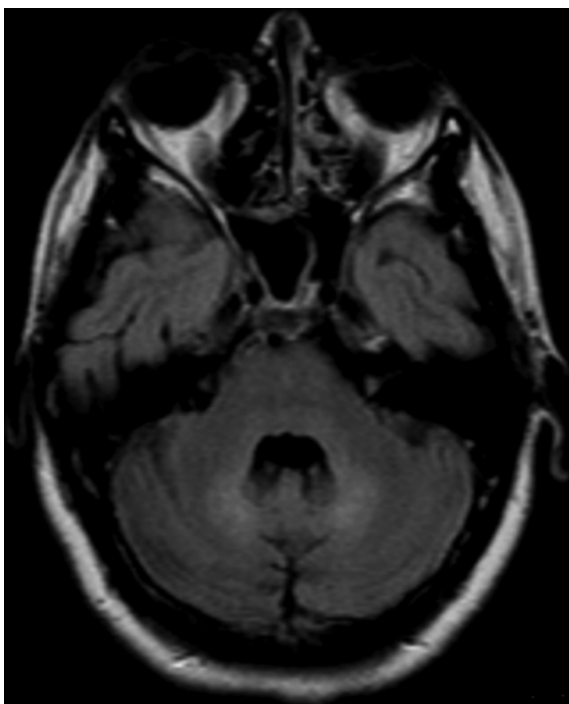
Increased signal in both cerebellar dentate nuclei in FLAIR examination in cranial magnetic resonance imaging.
